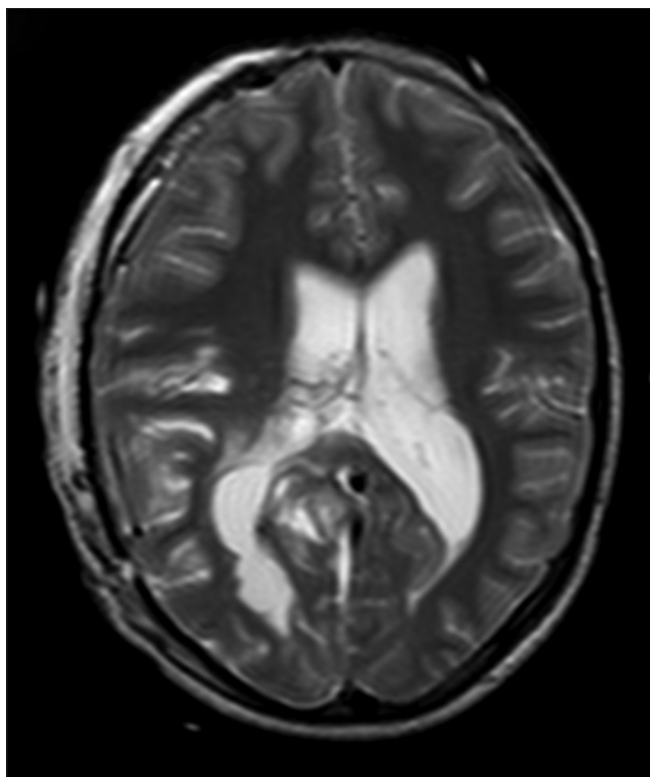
Post operative T2 axial MRI revealing clearance of the cysts
